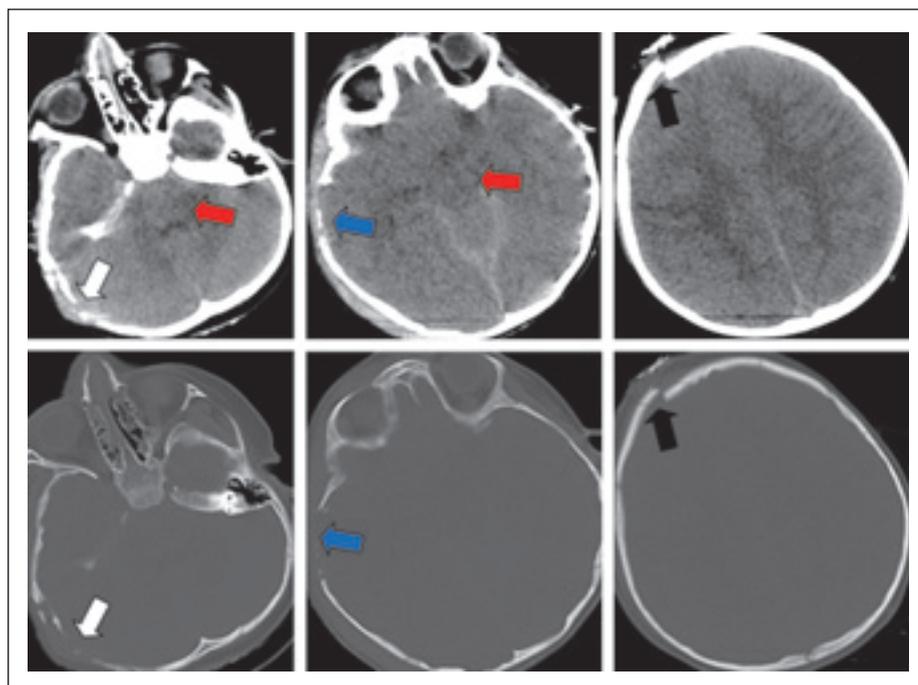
Axial pre-operative CT images of the same section, displayed in the brain (tissue) window (upper panel) and bone window (lower panel). The white arrow indicates the occipital fracture, the blue arrow points to the temporal fracture, the black arrow shows the displaced frontal fracture line, and the red arrow marks the obliterated brainstem cisterns. Widespread cerebral edema and traumatic subarachnoid hemorrhage are evident on the brain window.
